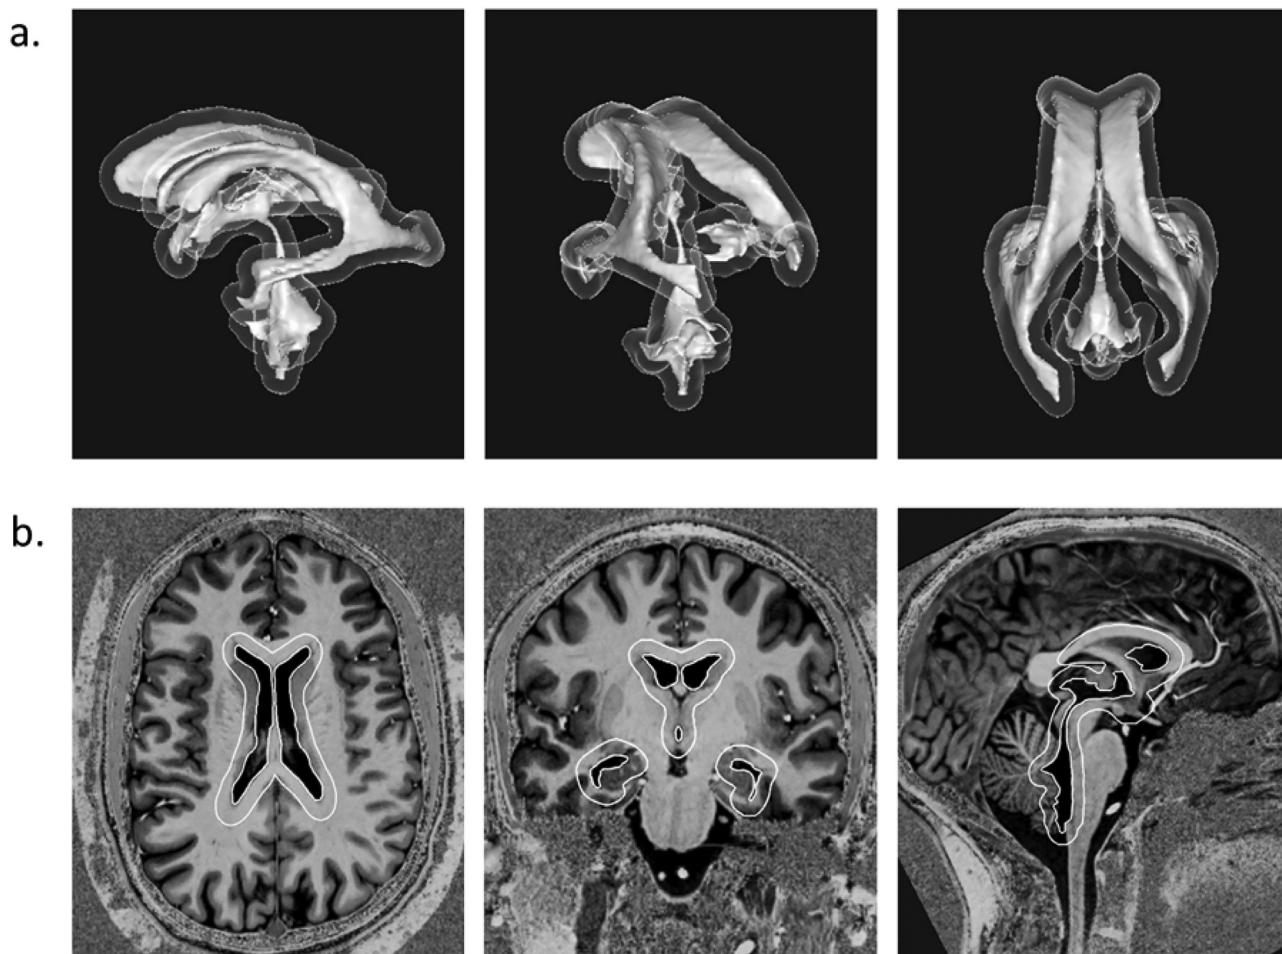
Visualisation of the periventricular space (PVS) which is delineated as a 5 mm rim around the ventricular system (a) in 3D (PVS: semi-transparent white; ventricular system: white); (b) on a 7 T MRI (MP2RAGE) scan (from left to right: axial, coronal, and sagittal planes).
